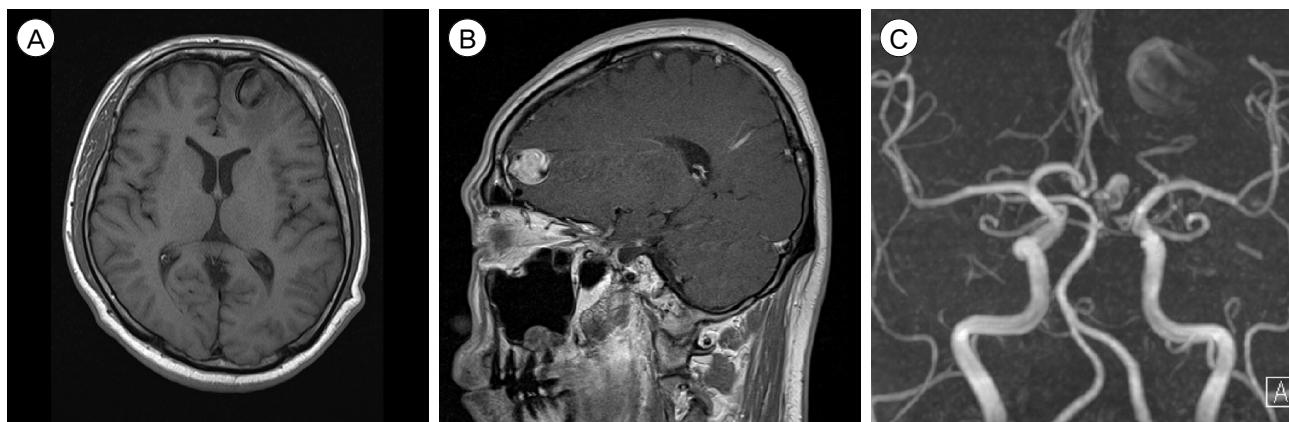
(A) Axial T1-weighted magnetic resonance imaging showing an enlarged vein at the left frontal lobe; (B) ectatic left frontal cortical vein ($19 \text{ mm} \times 15 \text{ mm}$) compressed brain; (C) magnetic resonance angiography showing vascular malformation, such as arteriovenous malformation on the left frontal lobe.
